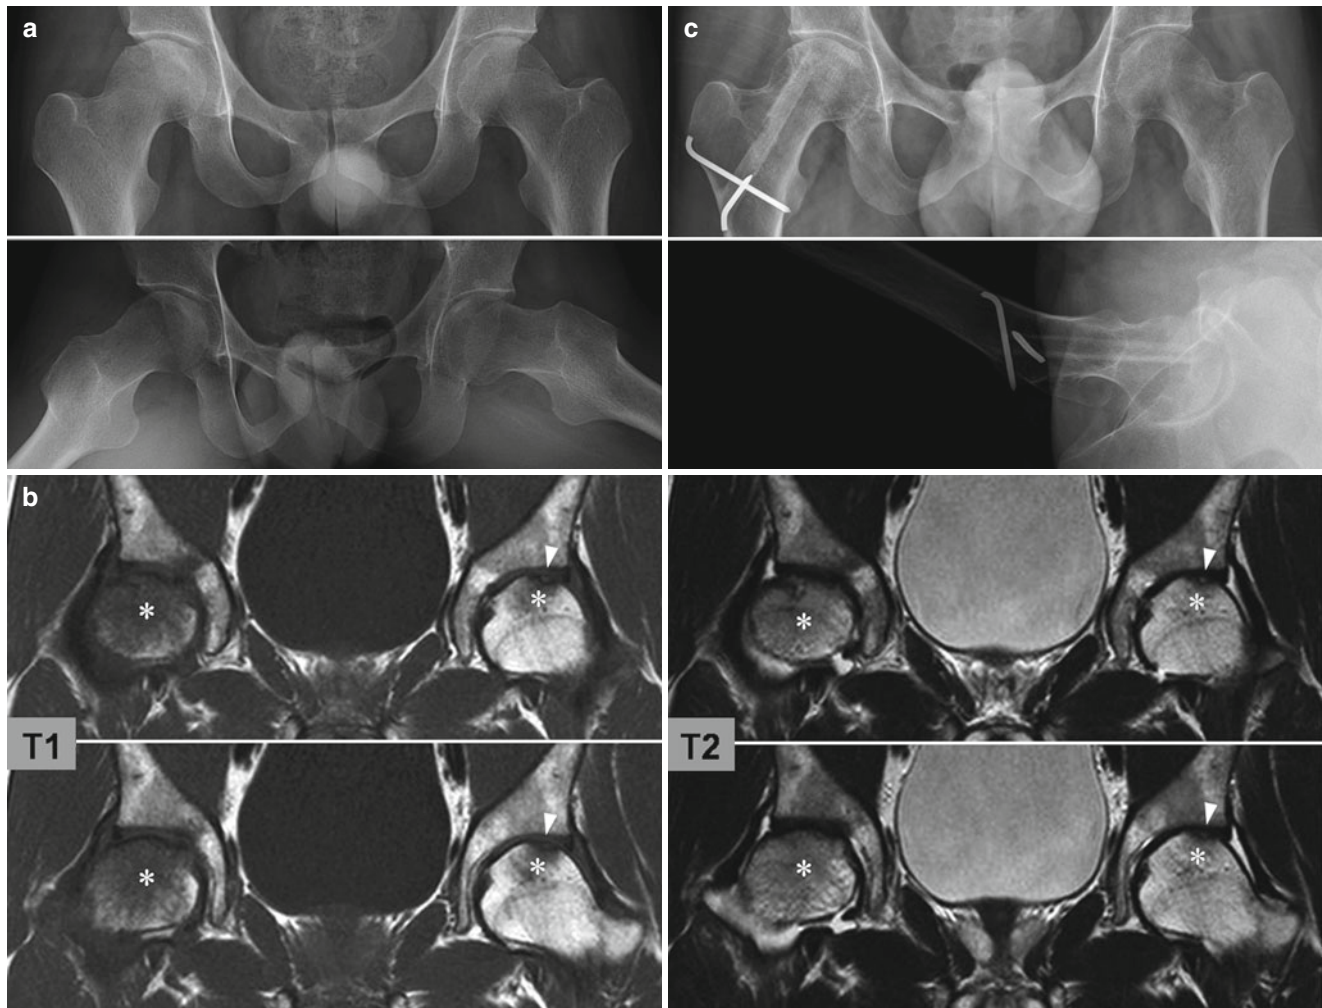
A 27-year-old man with bilateral fatigue-type subchondral stress fracture of the femoral head. (a) Plain radiographs taken 2 weeks after the onset of both left and right hip pain show linear increased density lesion in both femoral heads and collapse of the right femoral head. (b) MR images of the hip show a subchondral fracture line (arrow
